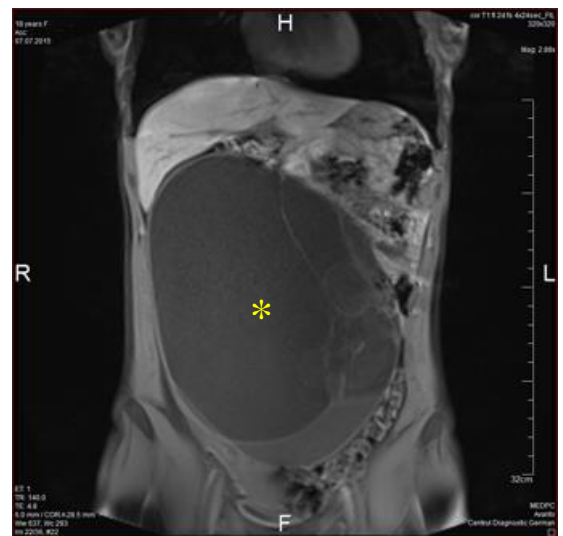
MRI (T1W, frontal plane): giant mucinous cystadenoma (*) of the right ovary
